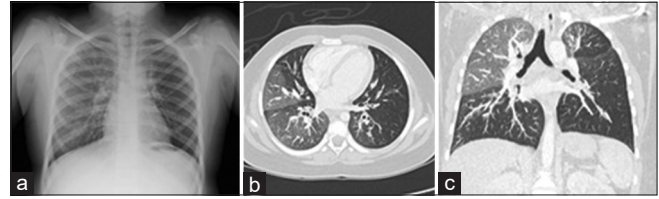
Radiological findings in patient with post-infectious bronchiolitis obliterans. (a) Plain chest X-ray showing lung hyperinflation, bronchial wall thickening, relative hyper lucency of left lung; (b) and (c): Chest computerized tomography scan showing mosaic perfusion pattern, vascular attenuation, and air trapping.
